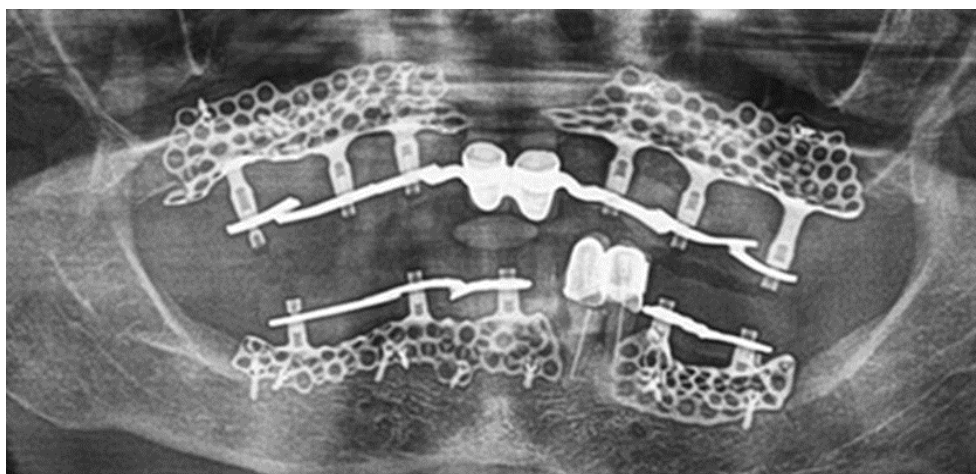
Panoramic x-ray image of the implant
